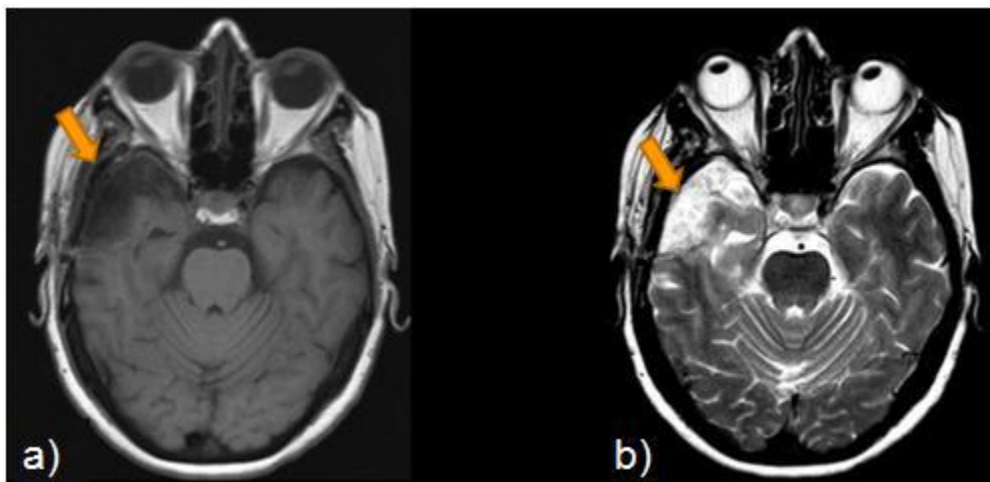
Axial MR image of TLE patient showing a right anterior temporal lobe lesion. (a) Hypointense T1 signal and (b) Hyperintense T2 signal.
